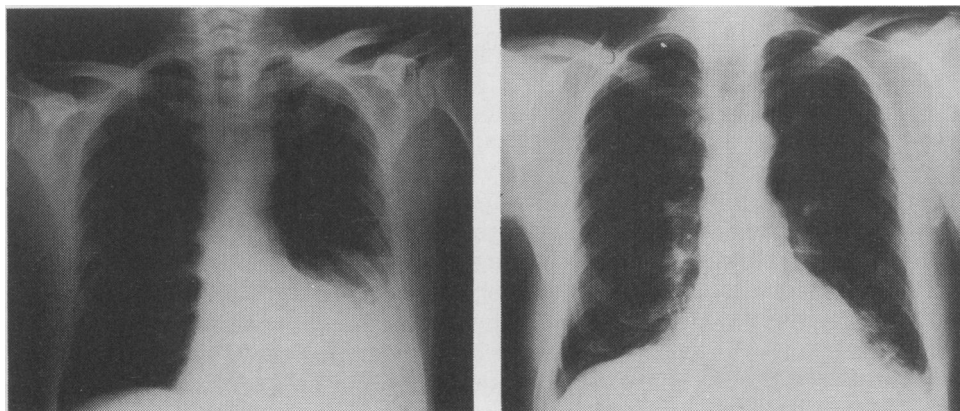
Chest X-rays taken on admission (left) and 10 days post-operatively (right).
